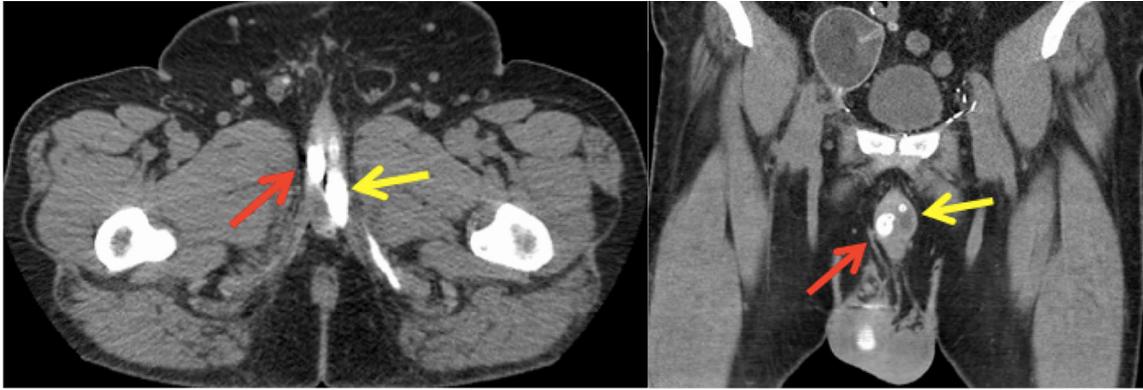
Axial CT image demonstrates the left cylinder (yellow arrow) is located more lateral than the right cylinder (red arrow). Erosion of the right cylinder into the urethral lumen was identified during surgery.
